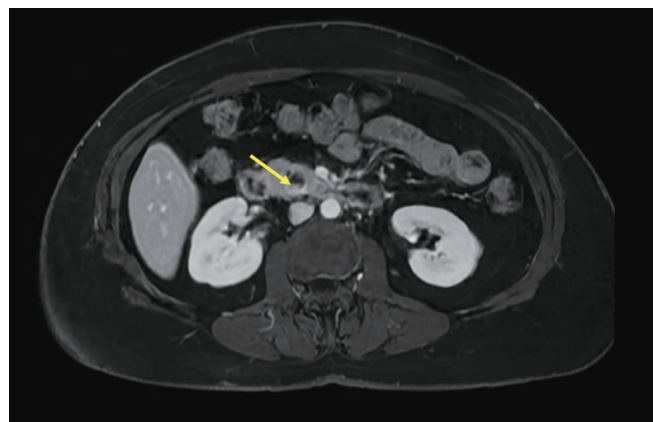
Axial T1 weighted, fat-saturated, contrast-enhanced portal venous phase MRI of a 57-year-old female displays enhancing mural nodularity measuring 5 mm (arrow) in a pancreatic cystic lesion measuring 1.7 cm in the uncinus process, a concerning feature. Endoscopic ultrasound with fine-needle aspiration is recommended based on these findings. Pathology revealed well-differentiated neuroendocrine tumor, undergoing surveillance.
